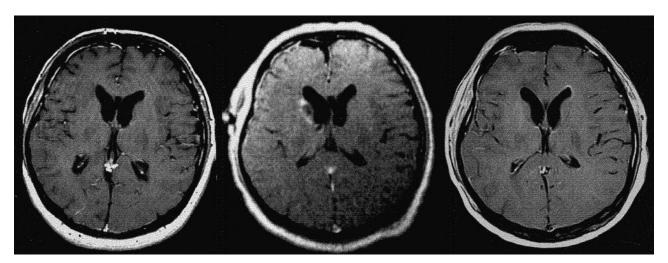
Surgically induced enhancement in the "uncertain" case of a 45-year-old man with a glioblastoma multiforme. The tumor is above the level of these T1-weighted images.
